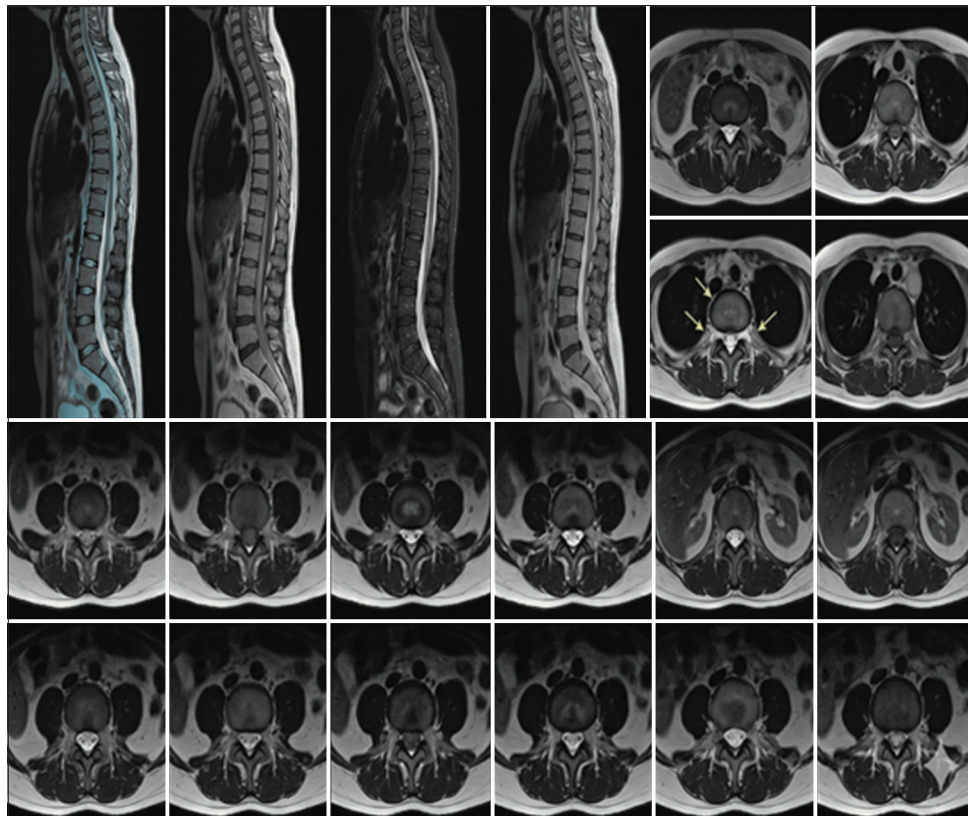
Sagittal magnetic resonance imaging dorso-lumbo-sacral spine (D1-L5): Multifocal T1-hypointense/short tau inversion recovery-hyperintense vertebral marrow lesions consistent with metastatic infiltration (arrows)
